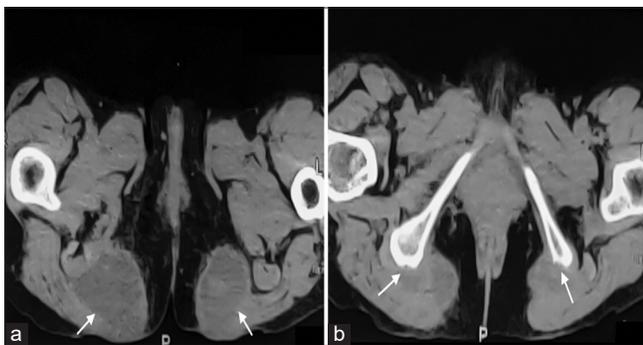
Computed tomography pelvis, axial, and non-contrast study (a) bilateral fluid attenuation lesions in ischiogluteal plane. (b) Mild cortical irregularity of bilateral ischial tuberosities (arrows).
